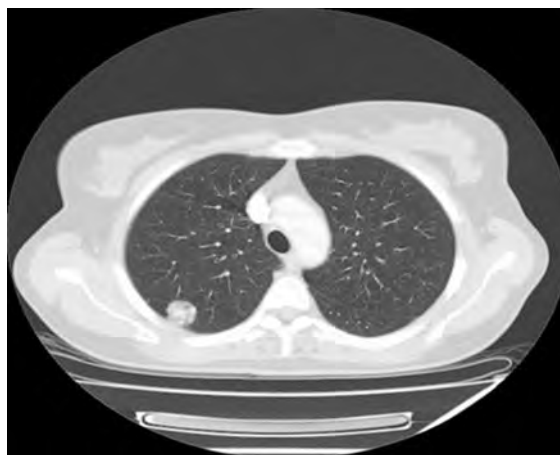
Computed tomography of a patient with peripheral tumor
